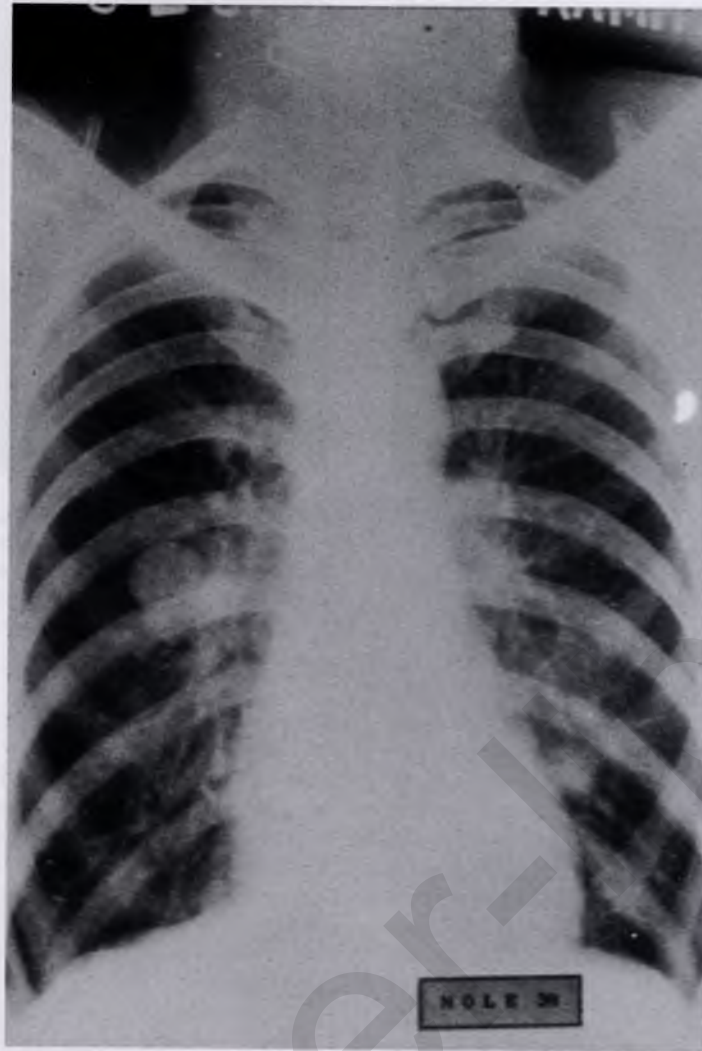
During hysterectomy procedures for the treatment of hydatidiform mole, it is wise to secure the vascular supply at the initiation of the operation to avoid villous deportation. This radiograph shows several nodules. When sampled, the pulmonary lesions revealed benign, hydropic villi, together with fibrosis. During 12-month follow-up, the pulmonary lesions spontaneously regressed.
